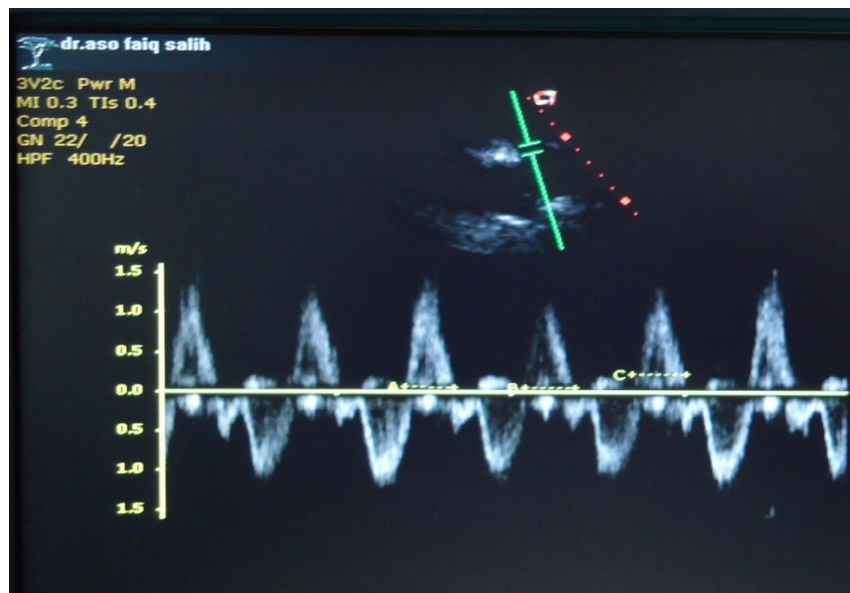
The measurements of the RV isovolumic relaxation time by using the pulse wave Doppler at the tip of the pulmonary valve.
